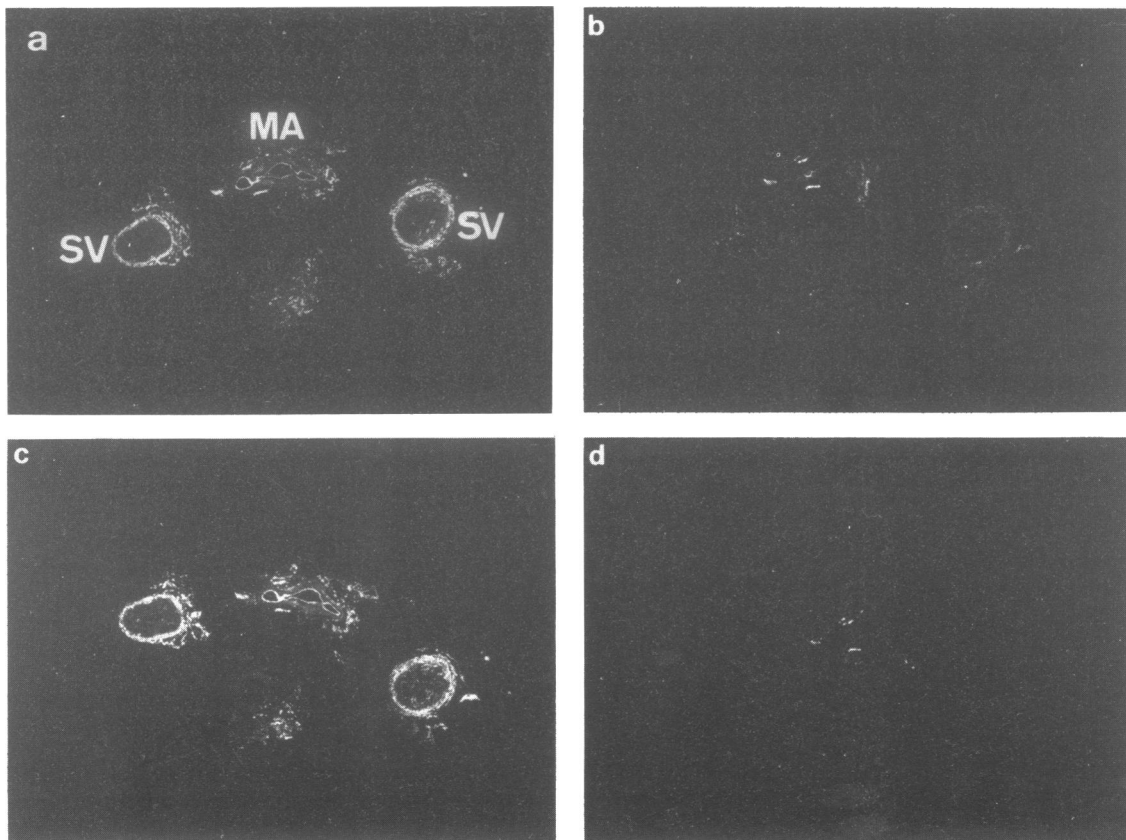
Photographs of X-ray film images showing the distribution of [^{125}I]-cyanopindolol ([^{125}I]-CYP) binding sites in serial sections of internal mammary artery (MA) and saphenous vein (SV). Sections were incubated with [^{125}I]-CYP ($50\ \text{pM}$) in the absence (a) and presence of ICI 118,551 ($70\ \text{nM}$) to show β_1 -adrenoceptors (b) or CGP 20712A ($100\ \text{nM}$) to show β_2 -adrenoceptors (c) or (–)-propranolol ($1\ \mu\text{M}$) to show non-specific binding (d). Note a high density of β -adrenoceptors localized to the intimal surface of the internal mammary artery and an even distribution of β -adrenoceptors on the medial smooth muscle of the saphenous vein (a) which were of the β_2 -subtype, since binding was absent in the presence of ICI 118,551 (b) and present in the presence of CGP 20712A (c). Localized binding of [^{125}I]-CYP to patches of adventitia were observed in the presence of (–)-propranolol (d), which was to dense aggregates of nuclei clustered in the lumen of small blood vessels.
